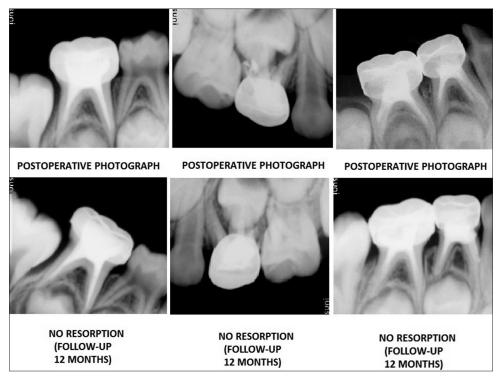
Radiographic assessment of root resorption after 12 months in pulpectomized deciduous teeth with Endoflas as an obturation material
